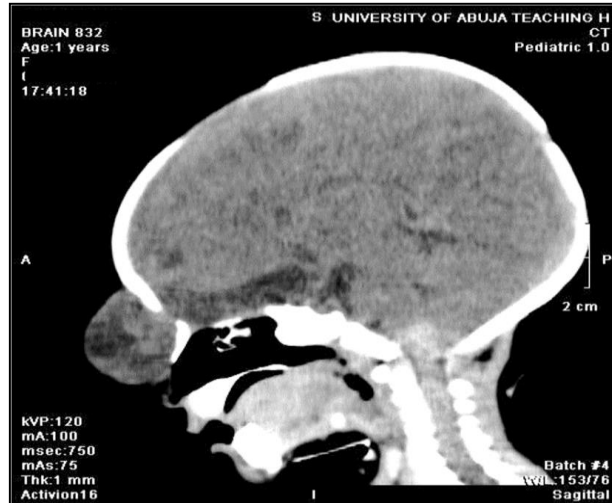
mid-sagittal computed tomography of the brain shows a well-defined frontoethmoidal osseous defect with protrusion of cranial contents
